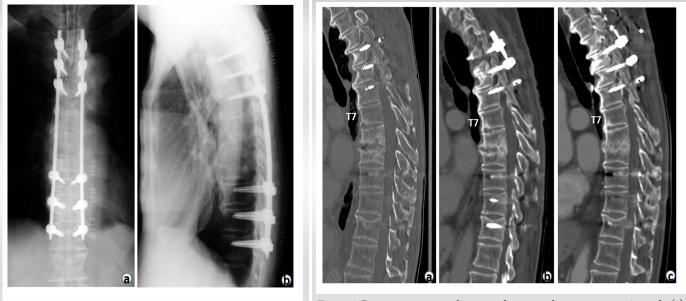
Post-operative anteroposterior (a) and lateral (b) X-rays.
